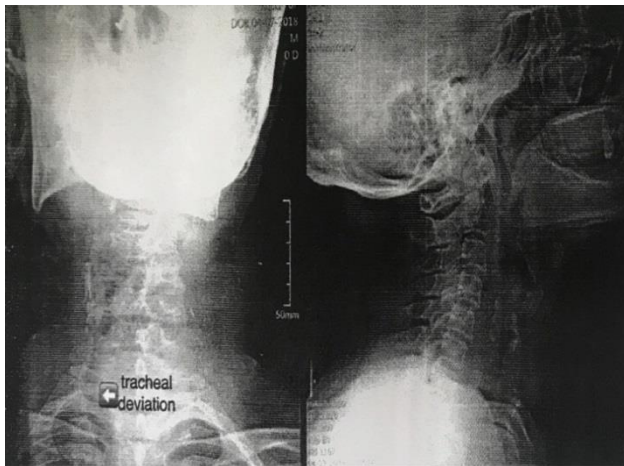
Chest X-ray shows tracheal shift to right side.
